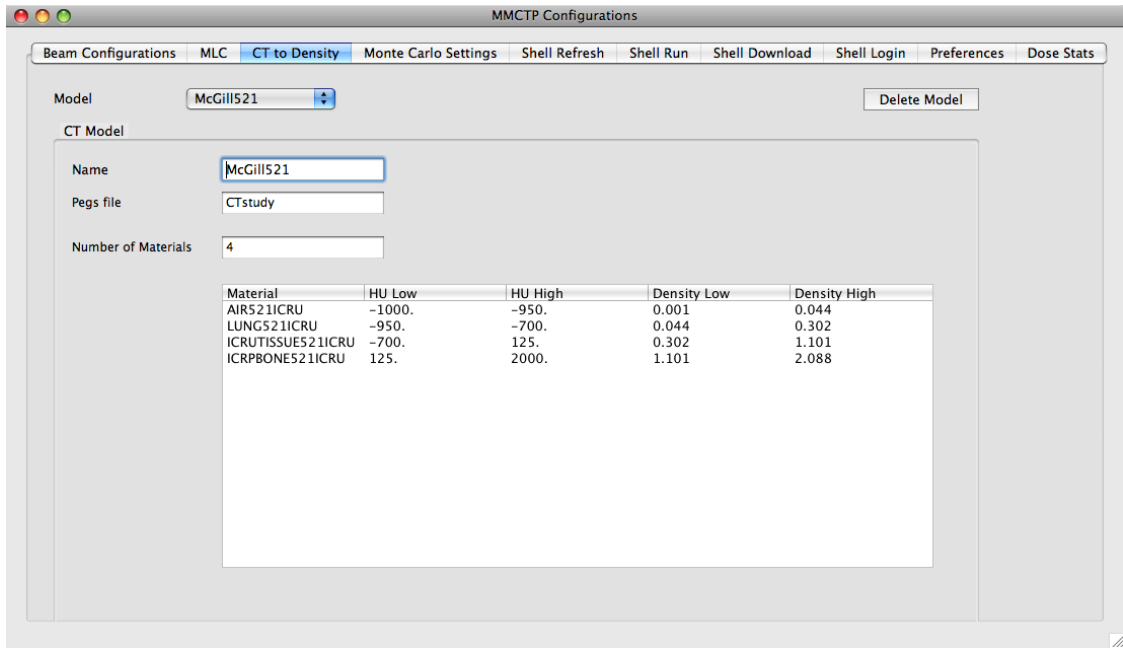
CT to density configuration tab, creation/modification of CT to density curves
